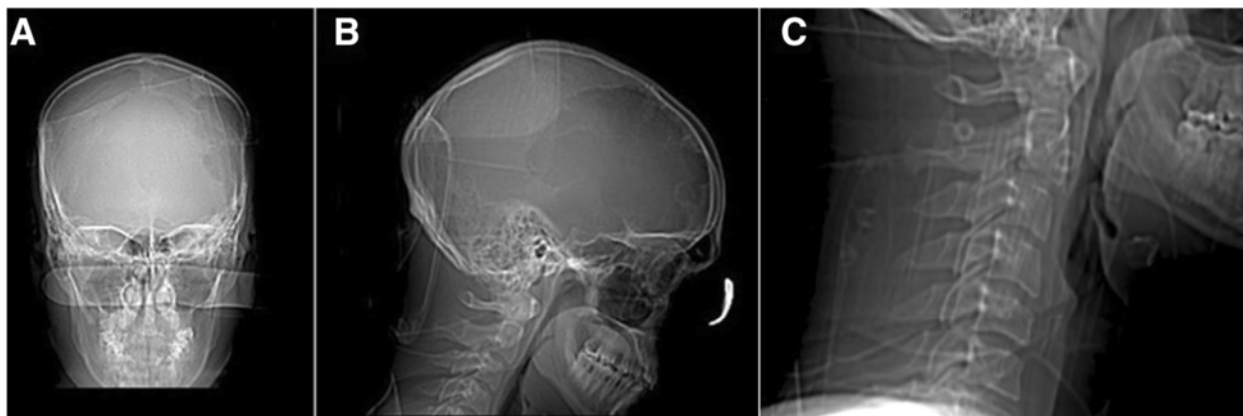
Plain skull films as obtained from CT-scouts: (A) Anteroposterior and (B) lateral projections show the skull preoperatively together with a view C) of the upper cervical spine (lateral view). No other lesions were evident, nor did we observe cervical fractures or misalignment. Sagittal and coronal sutures are visible.
